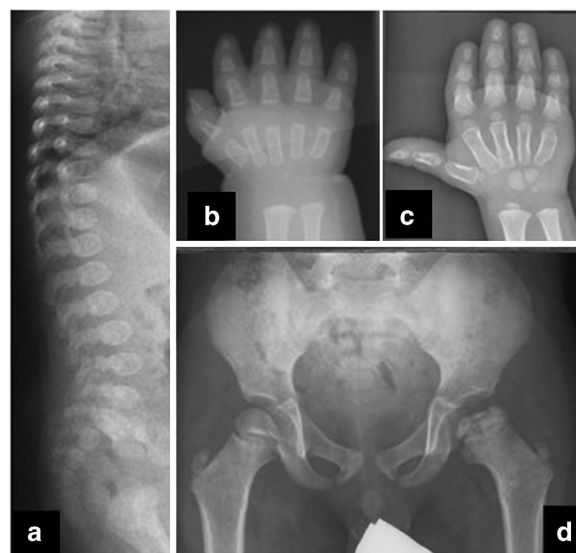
Radiological manifestations of geleophysic dysplasia. (a) AP view of the vertebrae (at 1 year of age), (b, c) hand X-ray (at 1 and 5 years of age) and (d) pelvic X-ray (at 5 years of age) of a GD patient. Note the ovoid vertebrae, the delayed bone age and cone-shaped epiphyses of the phalanges and the femoral epiphyseal dysplasia.
